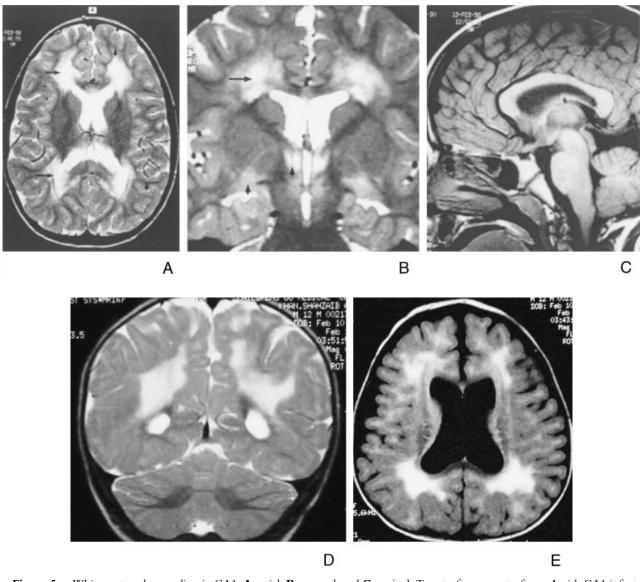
White matter abnormalites in GA1. A: axial, B: coronal, and C: sagittal. Twenty-five percent of non-Amish GA1 infants have an abnormal T2 hyperintense signal of supratentorial white matter that persists into childhood. Early myelinating structures appear normal, as does the volume of subcortical and interhemispheric fiber tracts. The T2 signal is particularly high in the periventricular regions of the frontal and parieto-occipital lobes (arrows) and preserved in the arcuate U fibers (arrowheads). B: On coronal view, patchy demyelination is evident in the perventricular white matter and genu of the corpus callosum. T2 hyperintensity is also seen in the gray matter of the basal and medial septal nuclei (arrowheads). C: On sagittal view, the volume and signal of the corpus callosum are normal. D (coronal): Terminal zone hypersignal contrasts with the normal appearance of early-myelinating cerebellar peduncles. E (axial): FLAIR imaging shows the extent of subcortical white matter abnormality in a 12-month-old patient.
